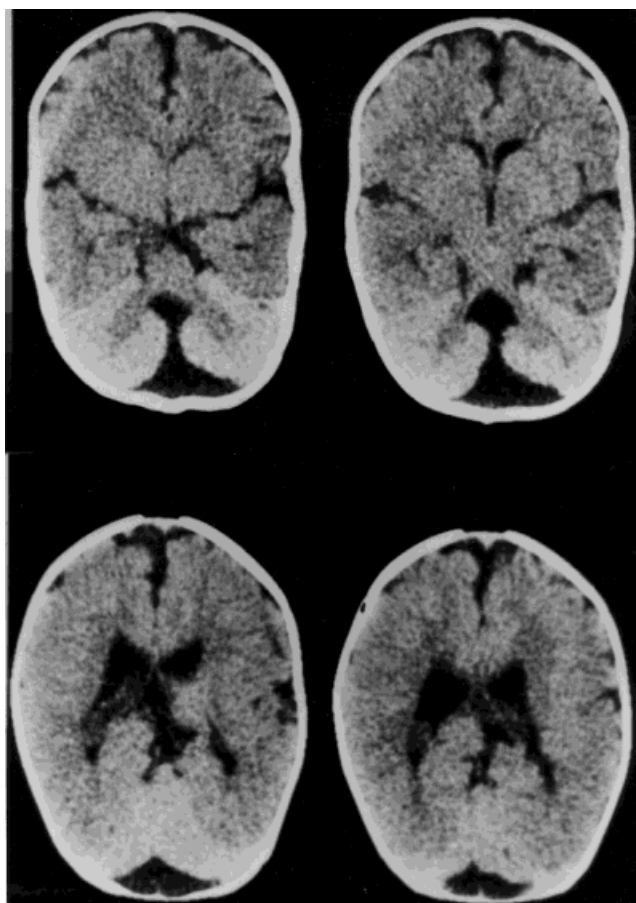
CT scan of the patient.
